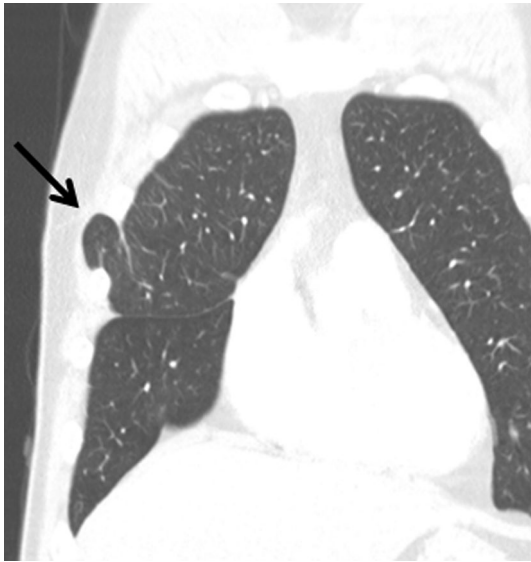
Postoperative intercostal lung herniation in a 49-year-old man treated with minimal invasive cardiac surgery for mitral valve replacement. Coronal chest CT image shows intercostal lung herniation (arrows) in the anterolateral portion of right 4th and 6th ribs
